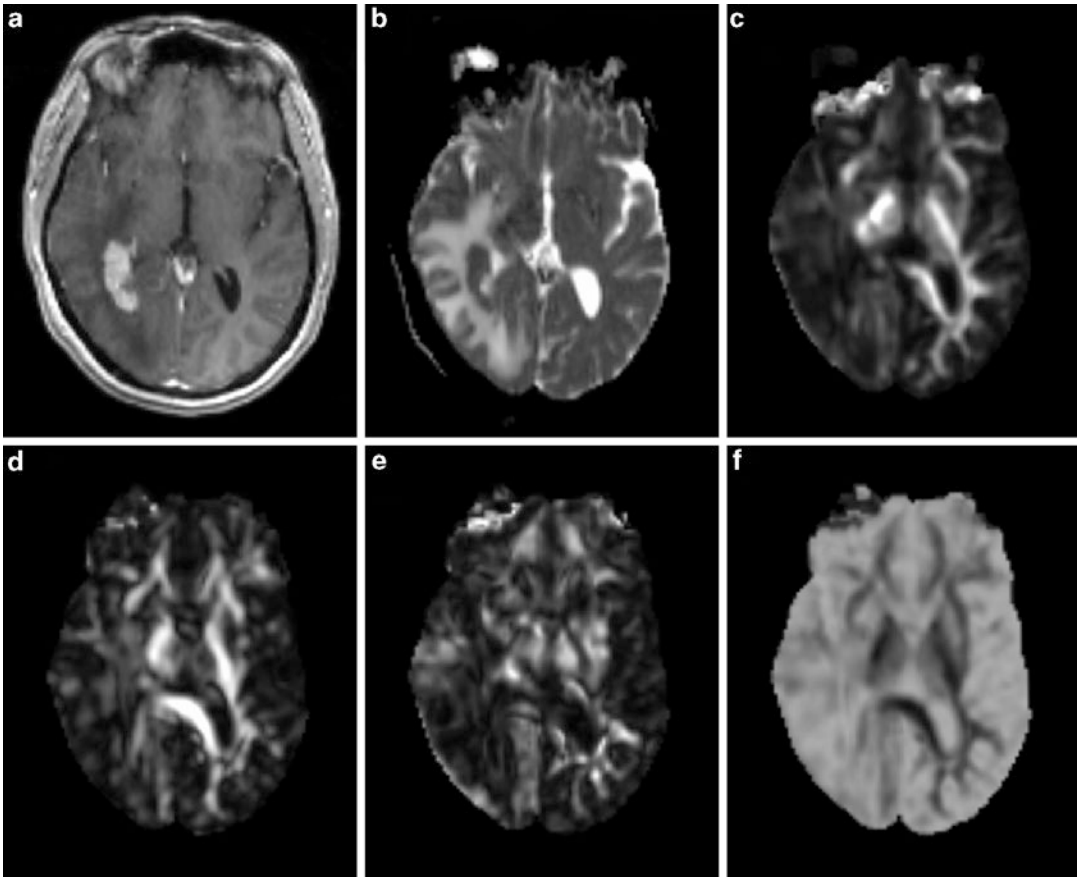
A 58-year-old female with primary cerebral diffuse large B cell lymphoma in the *right* peritrigonal area. Axial contrast-enhanced T1-weighted (a) shows a solid enhancing lesion with extensive edema. MD map (b) shows restricted diffusion of the enhancing part (0.80×10^{-3} /
